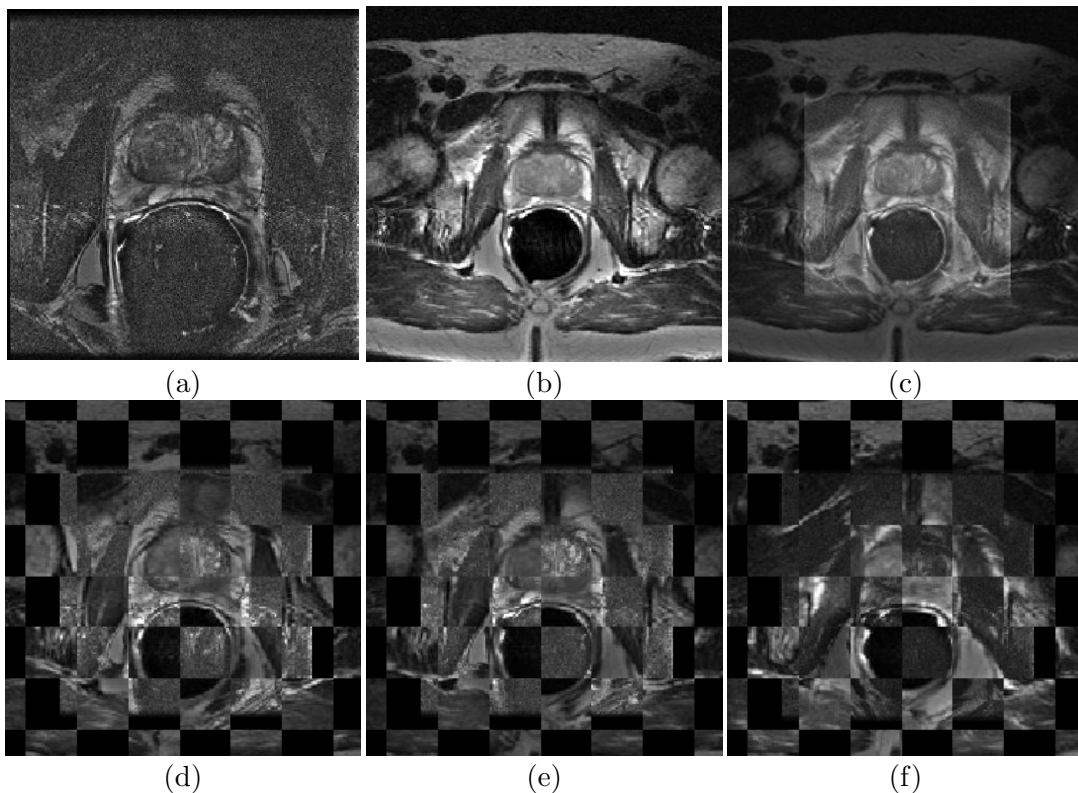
(a) Diagnostic MRI is affinely registered to (b) planning MRI. (c) The registered diagnostic MRI is shown in (d) overlaid onto (b). (e)-(h) Checkerboard patterns of four additional pairs of aligned diagnostic and planning MRI demonstrate accuracy of registration, as evidenced the continuity of prostate capsule and internal structures across checks.
